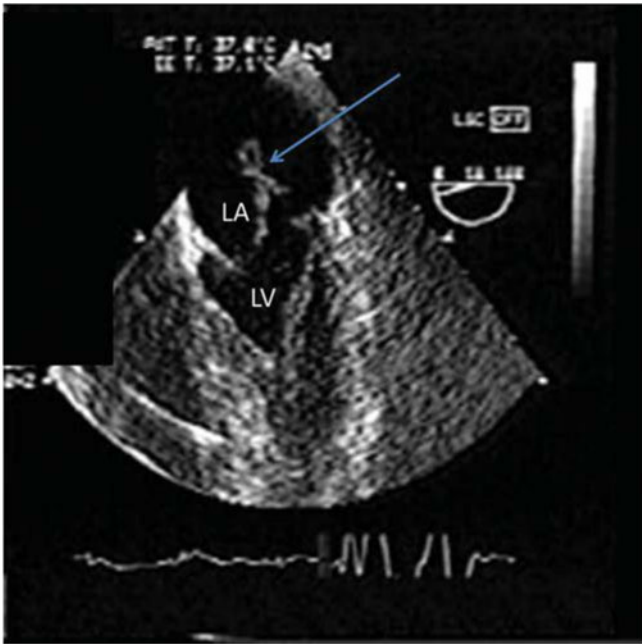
Two-dimensional transesophageal echocardiogram in a patient undergoing mitral valve replacement for a ruptured papillary muscle (*arrow*). LV, left ventricle; LA, Left atrium.
